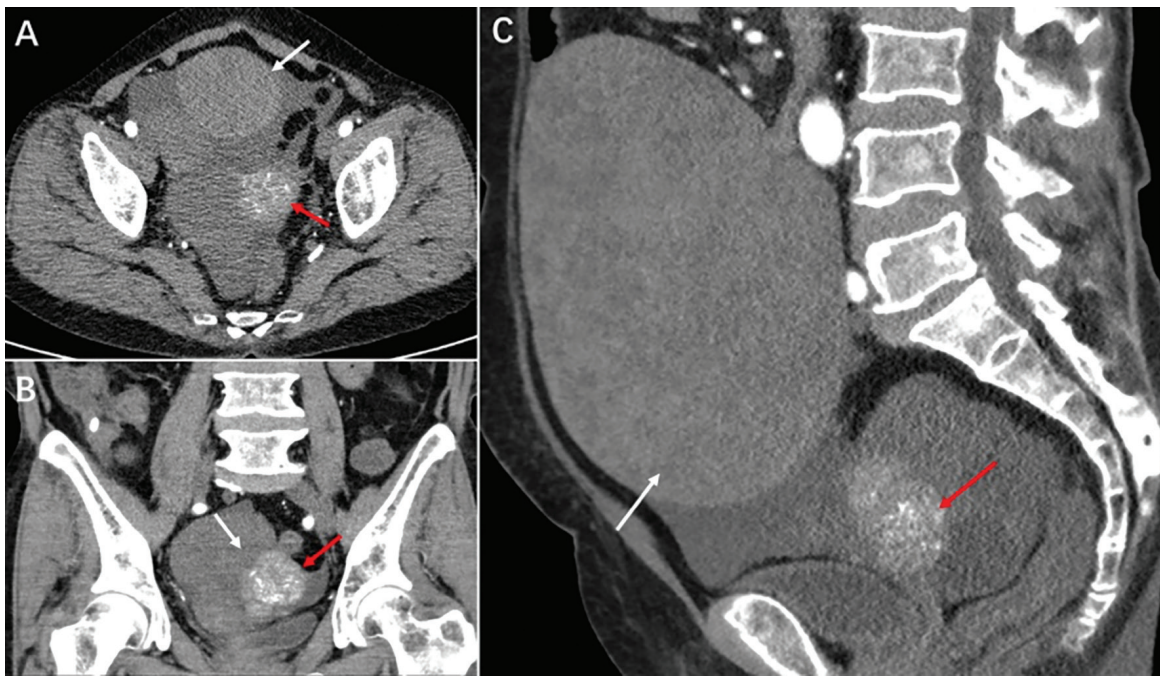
An abdominal computed tomography scan shows a cystic-solid pelvic mass accompanied by pelvic effusion
